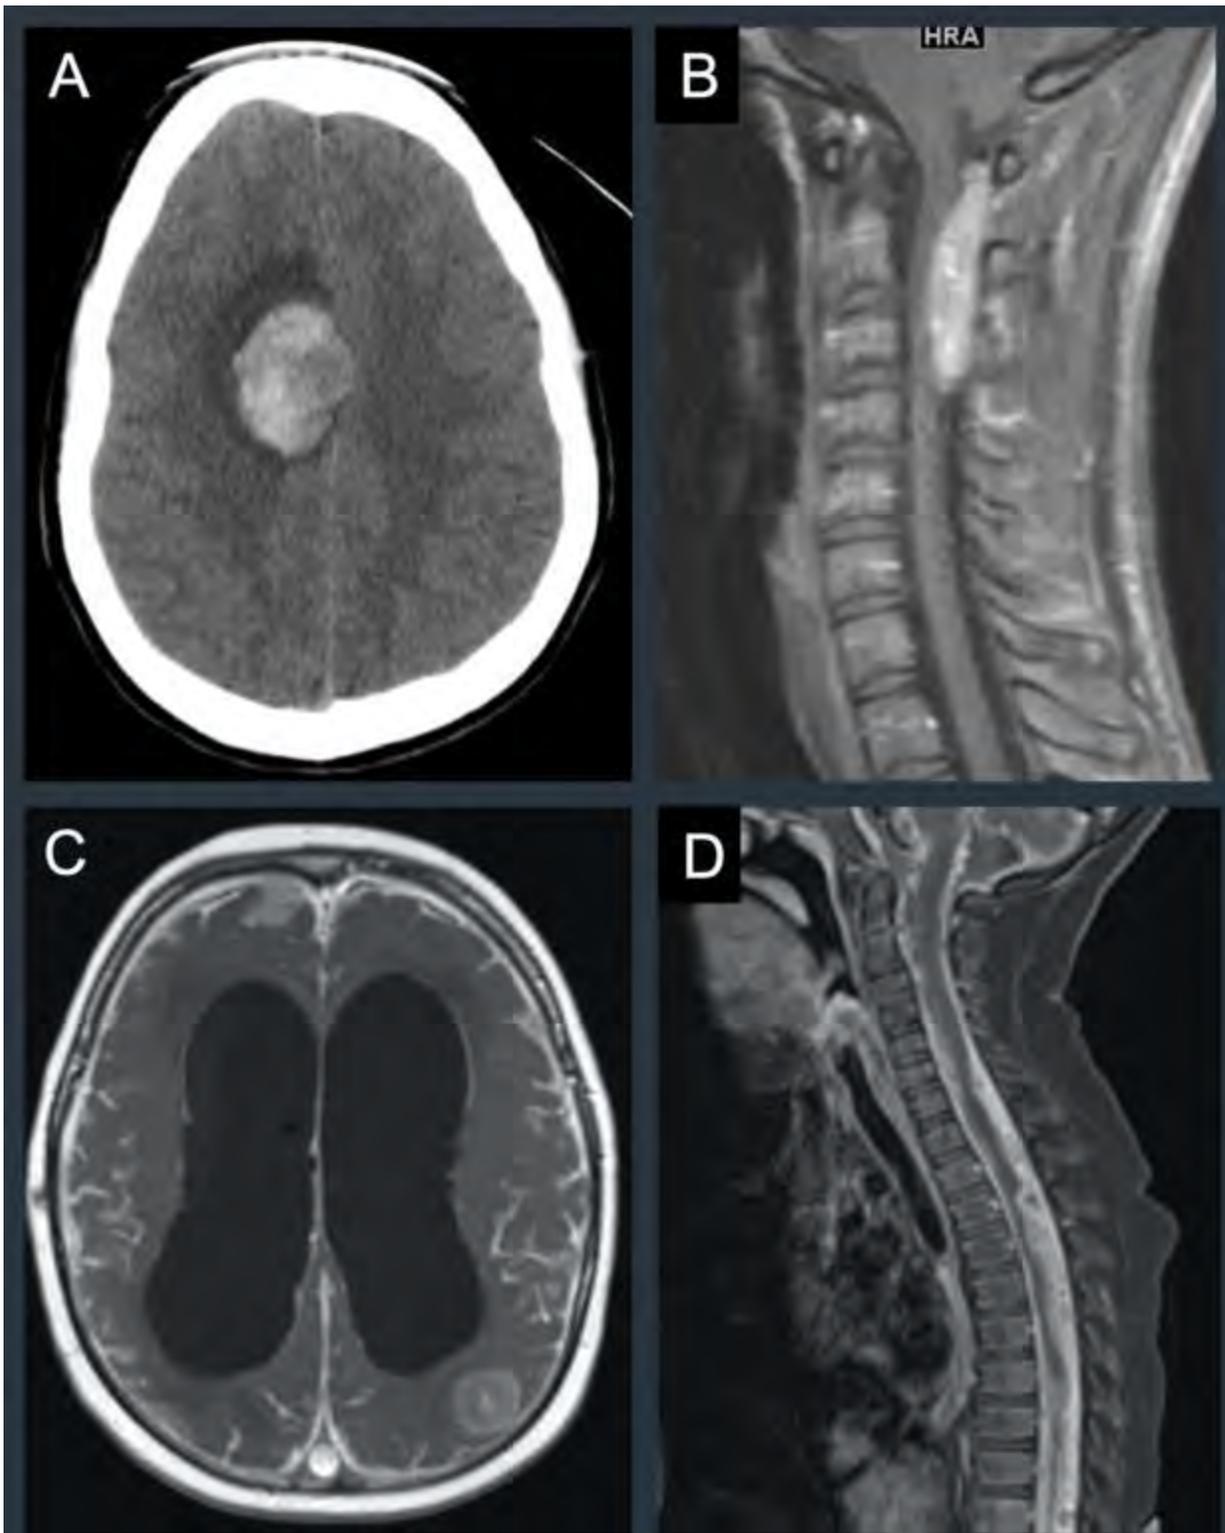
Pediatric primary melanocytotic disease. (A) CT demonstrates a hyperdense mass in the right paramedian frontal lobe of a teenage patient. This was a primary melanoma of the CNS complicated by hemorrhage. (B) Sagittal postcontrast T1-weighted image in a second teenage patient shows an extramedullary intradural enhancing cervical mass that was found to be a melanocytoma. This mass demonstrated intrinsic T1 hyperintensity (not shown). (C) Axial postcontrast T1-weighted MRI image in a child with diffuse melanomatosis demonstrates leptomeningeal enhancement and an enhancing left parietal lesion, which was likely leptomeningeal disease with parenchymal invasion. (D) Sagittal post contrast T1 cervical spine in the same patient shows diffuse extensive leptomeningeal enhancement.
